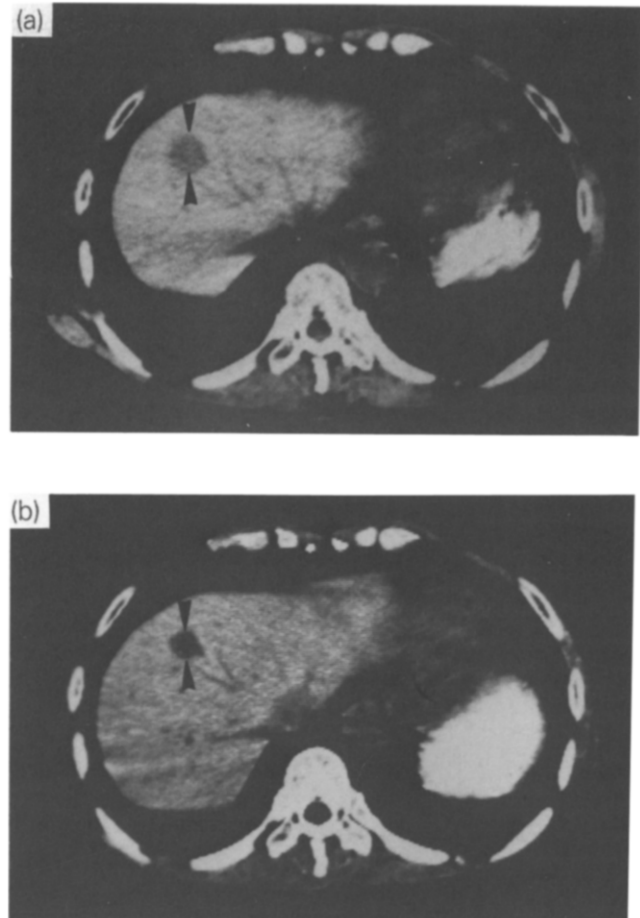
CT scan before and after laserthermia in case 3. (a) A small hypodense tumour and (b) A more hypodense and cystic area with decreased tumour size in the same plane, 5 months after laserthermia.
